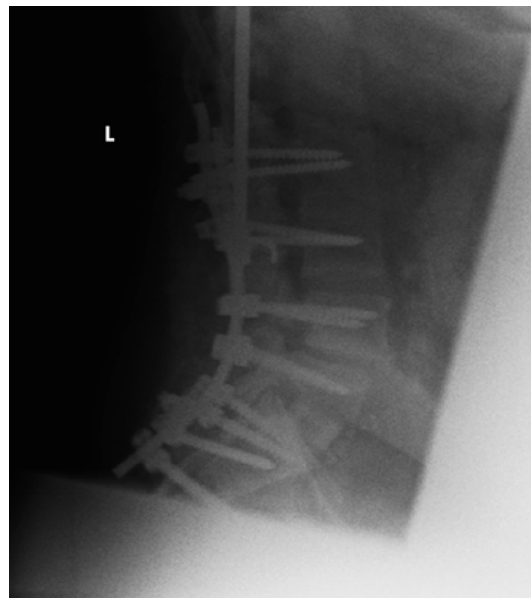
Upright lateral radiographs after extension of fusion to pelvis with L5-S1 ALIF placement to aid in fusion
